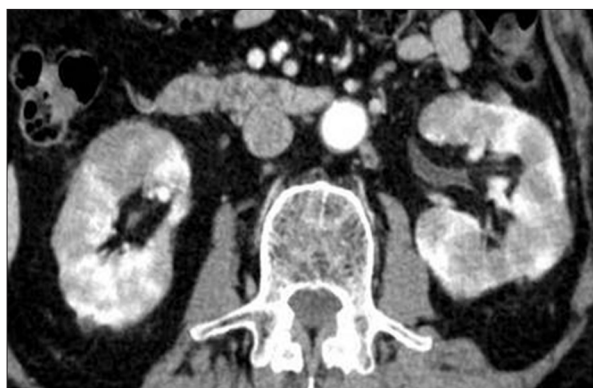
Contrast-enhanced computed tomography (CT). Contrast-enhanced CT image shows irregular findings in the kidneys and atrophy of the pancreatic parenchyma.
